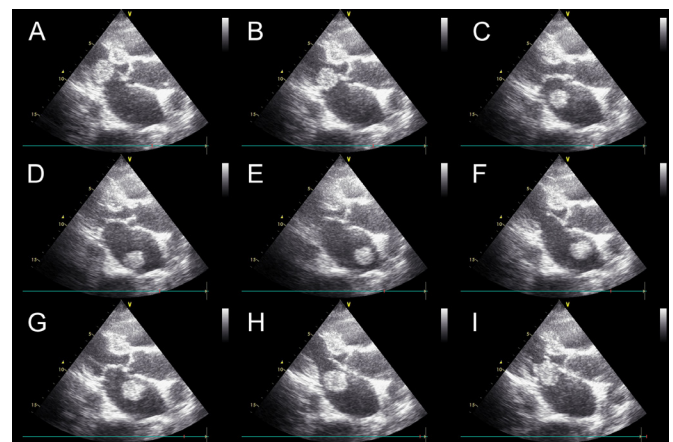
Transthoracic echocardiography series showing the movement of the floating mass in the left atrium (A-I).
